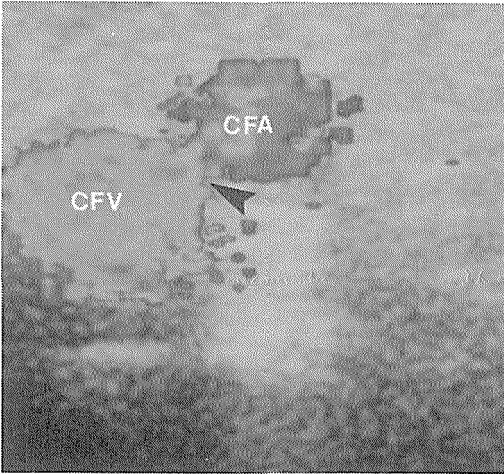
A transverse color and pulsed Doppler image of the AV fistula between the common femoral artery (CFA) and the common femoral vein (CFV) showing a communicating channel (arrow), and continuous, unidirectional, turbulent waveform.
